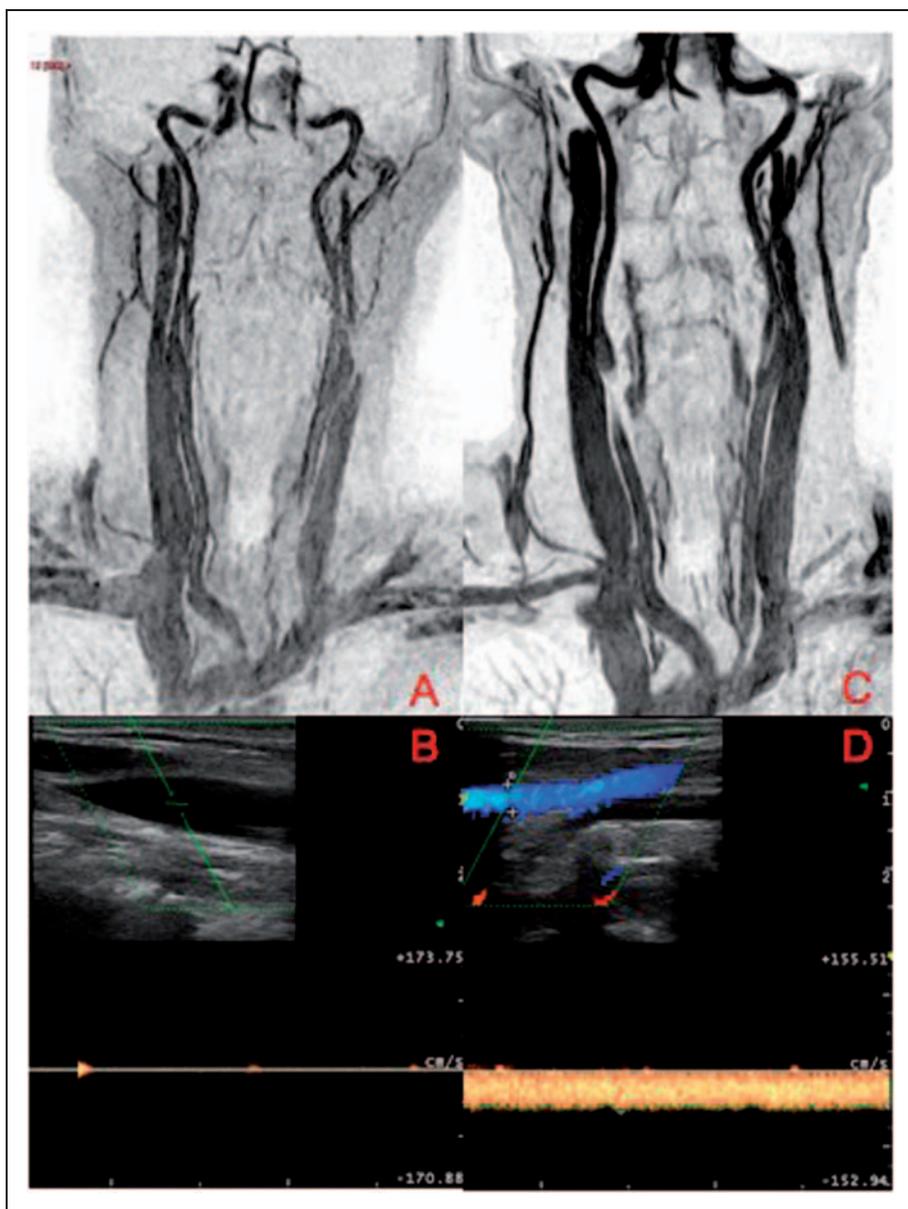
(A) Preoperative tip pencil sign at MRV investigation demonstrating an extrinsic obstruction of the IJV at mid cervical level. (B) Duplex demonstrating either the tip pencil sign in B-mode, or the absence of flow at PW Doppler. (C) Postoperative repair of the IJV demonstrated at one year MRV. (D) Triplex demonstrating the flow recovery in the IJV at one year. Doppler flow was assessed at 300 ml/min.
